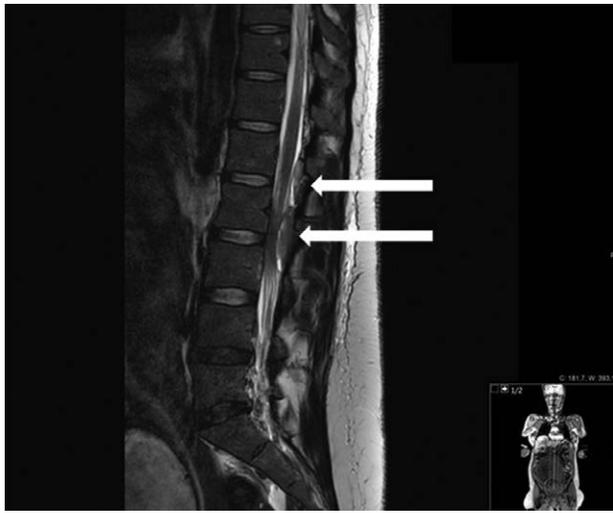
MRI performed at 35 + 3 weeks of gestation revealing prominent venous malformations in the epidural space (arrows). MRI indicates magnetic resonance imaging.
